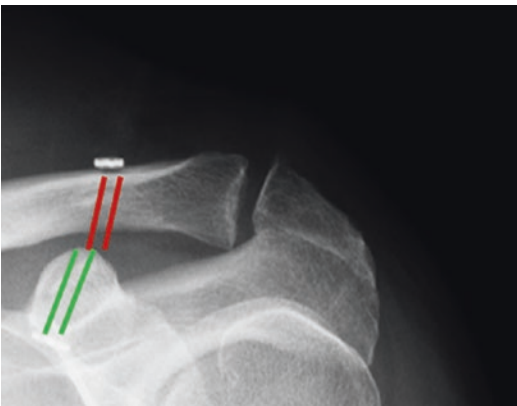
Left shoulder, careful evaluation of postoperative X-rays showing that the clavicular and coracoid tunnels are not coaxial
